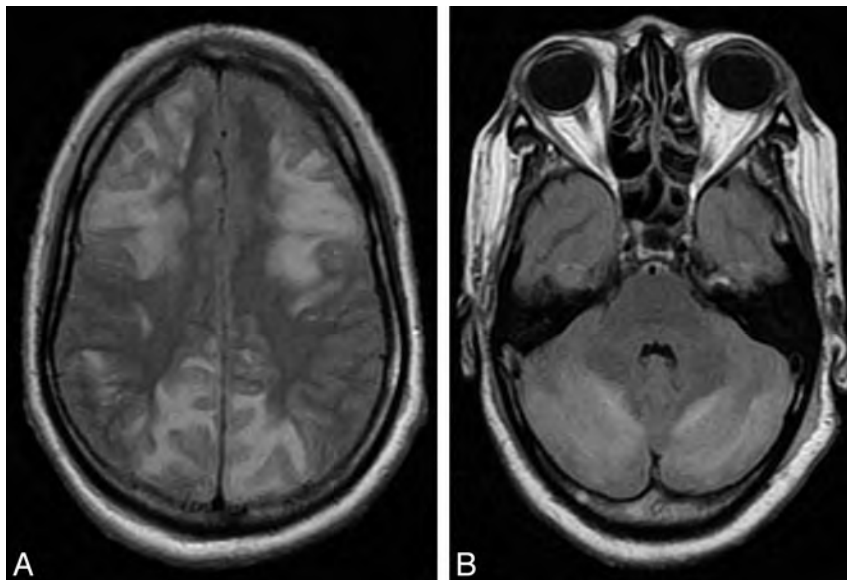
FLAIR MR images of the brain of a 19-year-old woman with antepartum eclampsia showing involvement of bilateral frontal, parietal (A), and cerebellar (B) regions.
